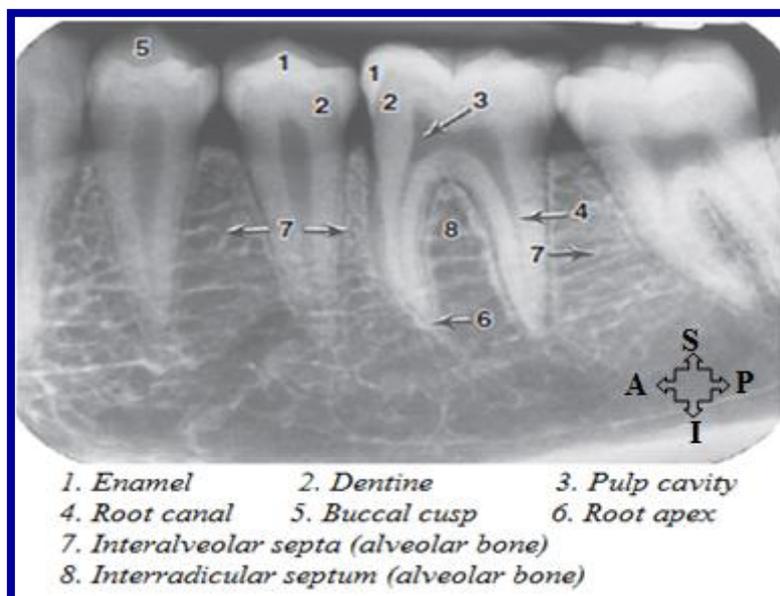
Lateral radiograph showing the different parts of teeth (Adapted from Moore *et al.*, 2010)
